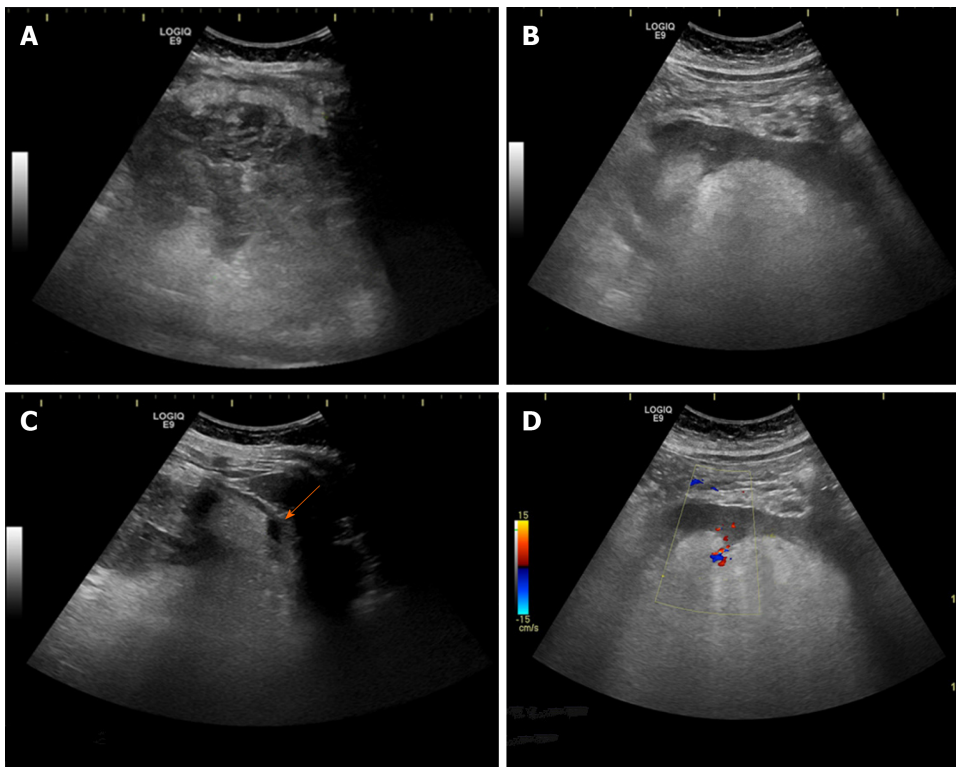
Ultrasound images of a giant nonhomogenous lump in the left kidney area. A: The part of the lump located in the left kidney area was hypoechoic with a strong stripe echo; B: The lump caused the left kidney to move to the middle abdomen. The inner part of the lump near the left kidney was hyperechoic; C: A stripe-shaped echoless zone was seen around the lump (arrow); D: The color Doppler flow image showed some spot-like blood flow signals around the lump.
